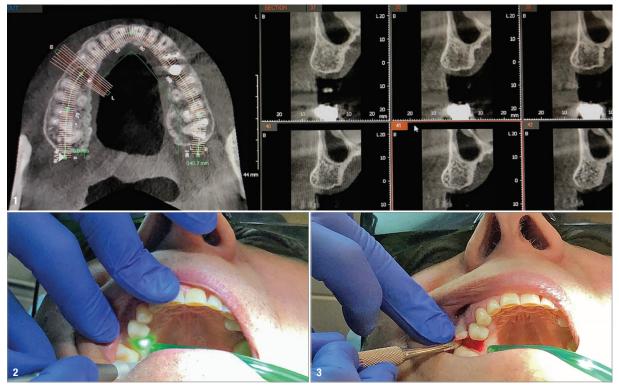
A CBCT scan was taken pre-op. Fig. 2: Flap incision using a LightWalker Nd:YAG laser head (200 μm diameter fibre, 3 W, 70 Hz, MSP). Fig. 3: Flap reflection was carried out with a Prichard elevator.
